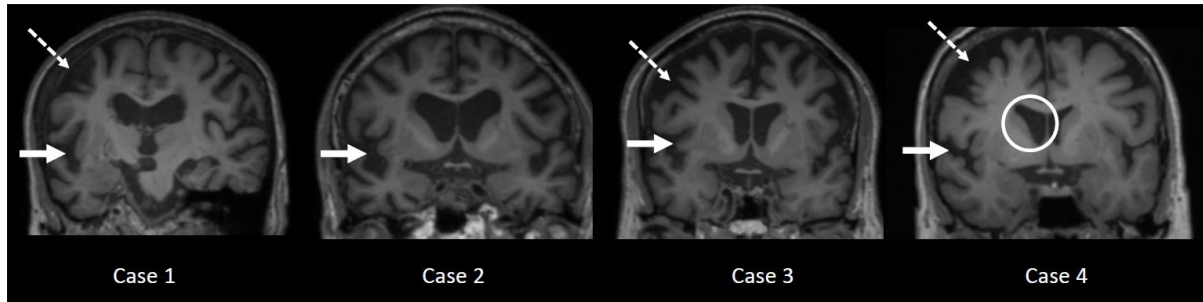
Coronal MRI images of the four right-nfvPPA participants. The sections are located at the temporal-frontal junction and demonstrates prominent atrophy in the right hemisphere (arrow).
